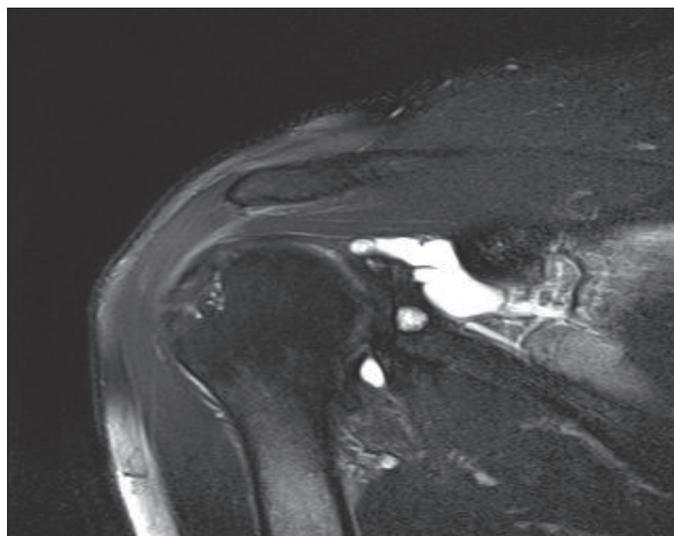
T2-weighted magnetic resonance image demonstrating inferior labral tear and a paralabral synovial cyst extending to the infraspinatus muscle and edema pattern in the infraspinatus muscle.
